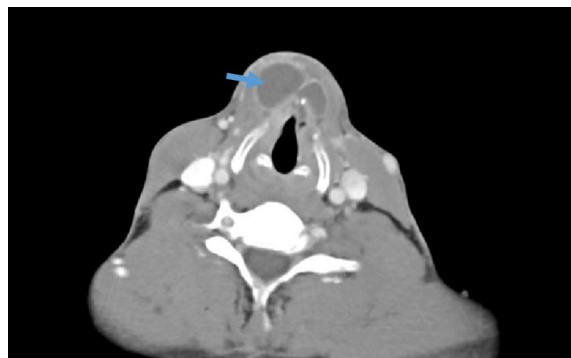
Computed tomography of soft tissue neck revealed multiloculated fluid collections 1.7 x 3.0 cm [Arrow]
